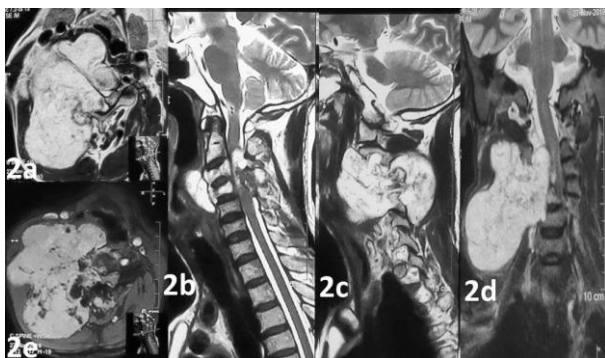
Preoperative magnetic resonance imaging of cervical spine (a) axial; (b,c) sagittal; (d) coronal T2 weighted images showing large hyperintense well defined lobulated predominantly exophytic lesion involving right side of vertebra with significant compressing and pushing the spinal cord on
